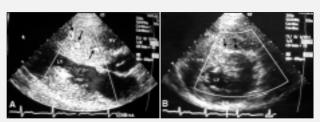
A) twin G, long axis. Enlarged septal coronary branchs are showed with color Doppler (arrows). B) twin G, short axis. An enlarged perforating septal branch is showed with color Doppler (arrows).
